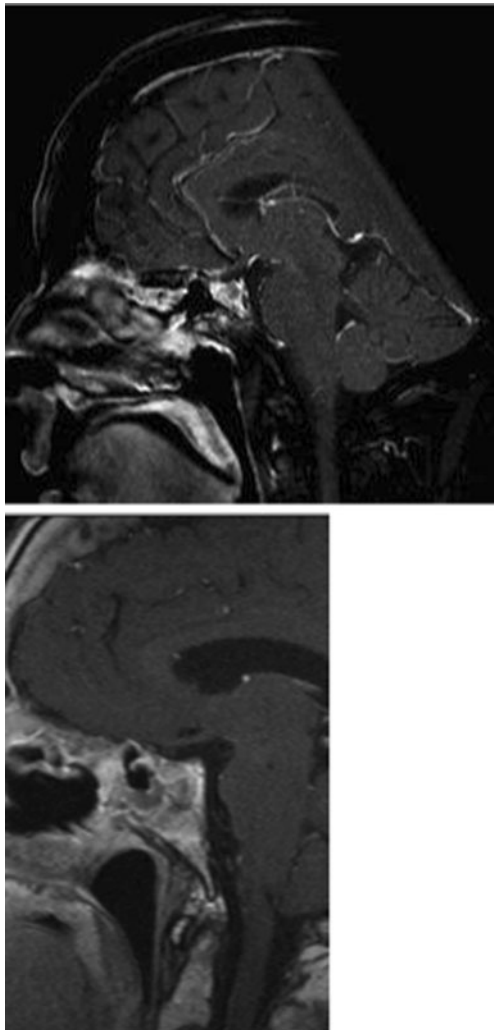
Patient 1 (above) and patient 2 (below) post-operative sagittal MRI scans (T1 with gadolinium)
